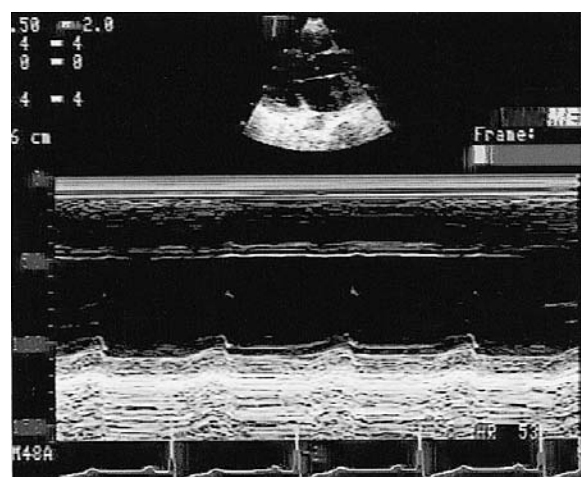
The 2-dimensional echocardiography revealed increased left ventricular dimension (left). M-mode at the mid-ventricular septum revealed increased E-point septal separation (EPSS) (right).
